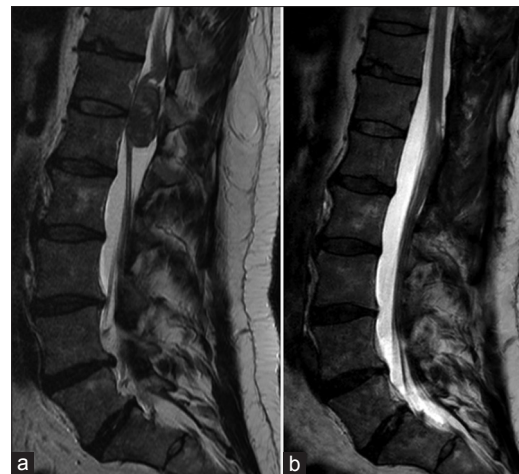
(a) and (b) Sagittal T2-weighted MRI demonstrating intradural extra axial lesion (left). Sagittal T2-weighted MRI at one year demonstrating tumor excision with no evidence of recurrence (right)
